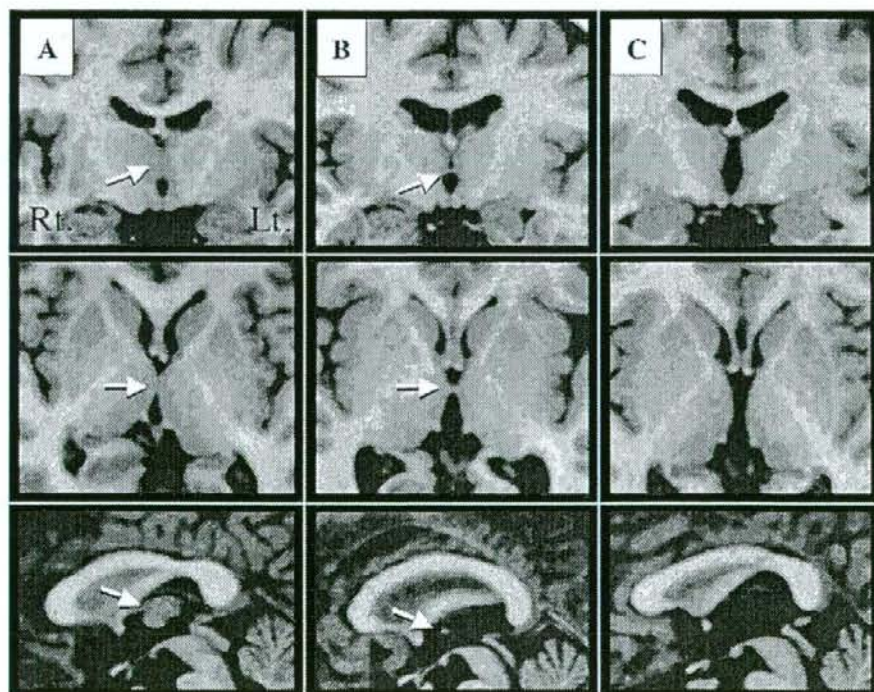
Coronal (upper), axial (middle), and midsagittal (lower) views of the T1-weighted MR images (1-mm slice thickness) in subjects with (A) and without (B, C) the adhesio interthalamica (AI). Arrows indicate the position of the AI. Subject B has a narrow connection of two coronal slices (2 mm) between the thalami but was without an AI according to our definition (see text).
